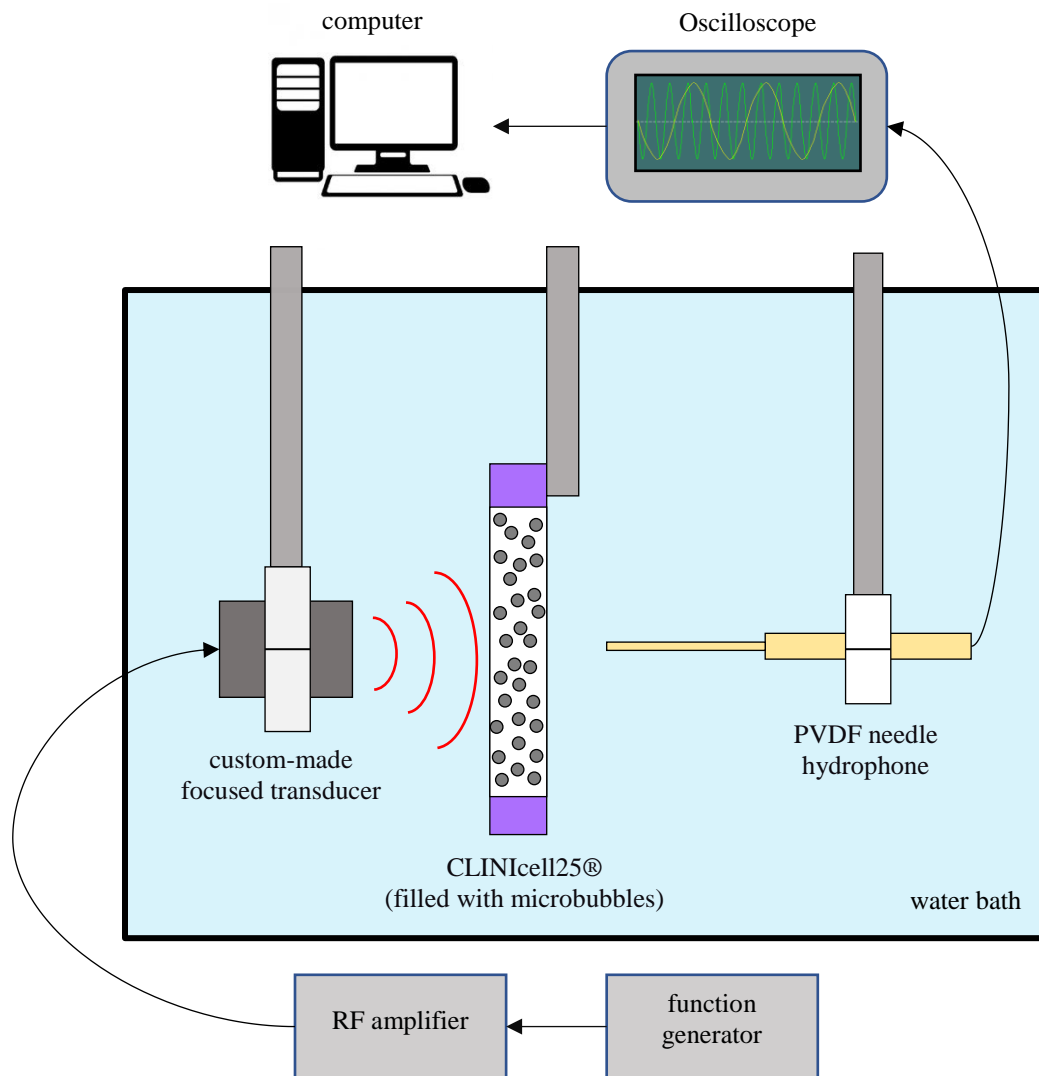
Instrument setup for measuring acoustic attenuation by microbubbles. A CLINICell was placed vertically in between a custom-made transducer and a PVDF needle hydrophone. An ultrasound pulse sent by the custom-made transducer went through the CLINICell and was received by the needle hydrophone.
